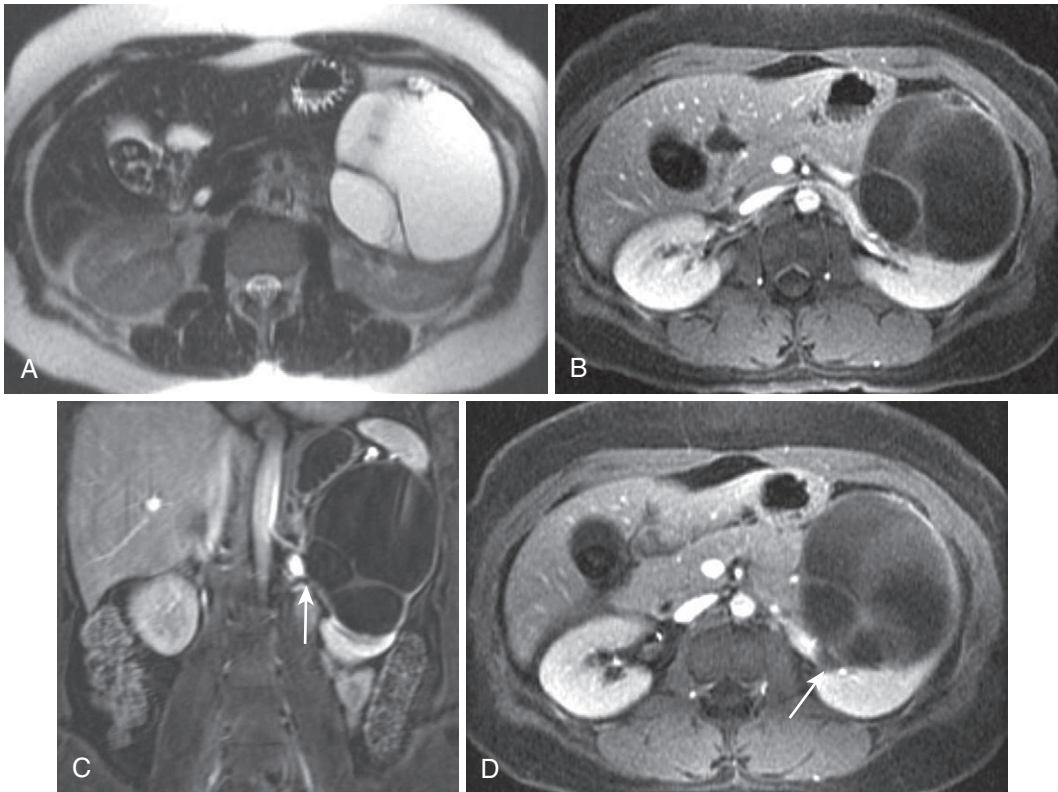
Multilocular cystic nephroma. The axial heavily T2-weighted (A) and postcontrast (B) images reveal a large multiloculated cystic lesion in a 45-year-old woman. The coronal postcontrast image (C) portrays the size of the lesion and subtle medial protrusion (arrows in C and D), corroborated on the coronal enhanced image (D), conforming to herniation into the renal pelvis at surgical resection.
